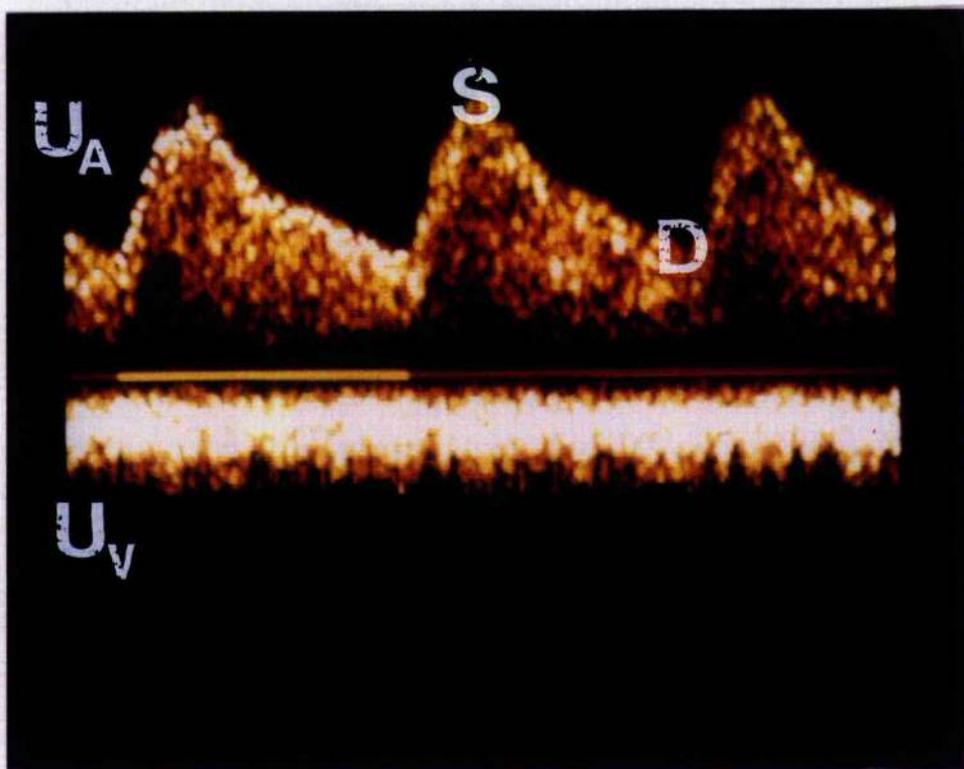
Doppler flow velocity waveform of an umbilical artery (U_A) and the umbilical vein (U_v). The peaks in the U_A correspond to systole (S) in the cardiac cycle while the troughs reflect diastole (D)
